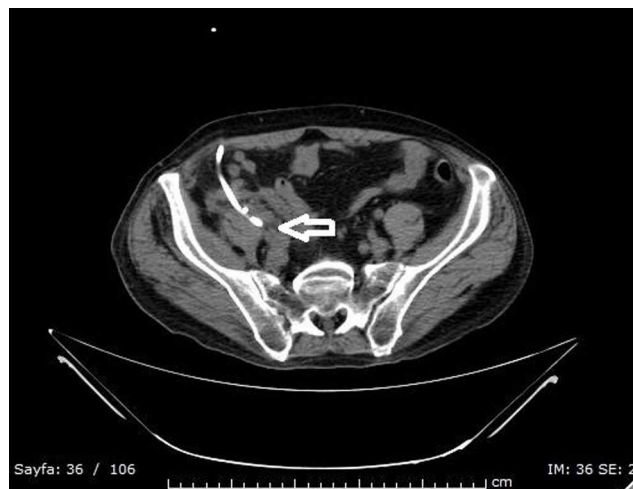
In the non-contrast axial section of the abdominal CT; drainage catheter extending to abscess area in the right psoas muscle (hollowarrow).
